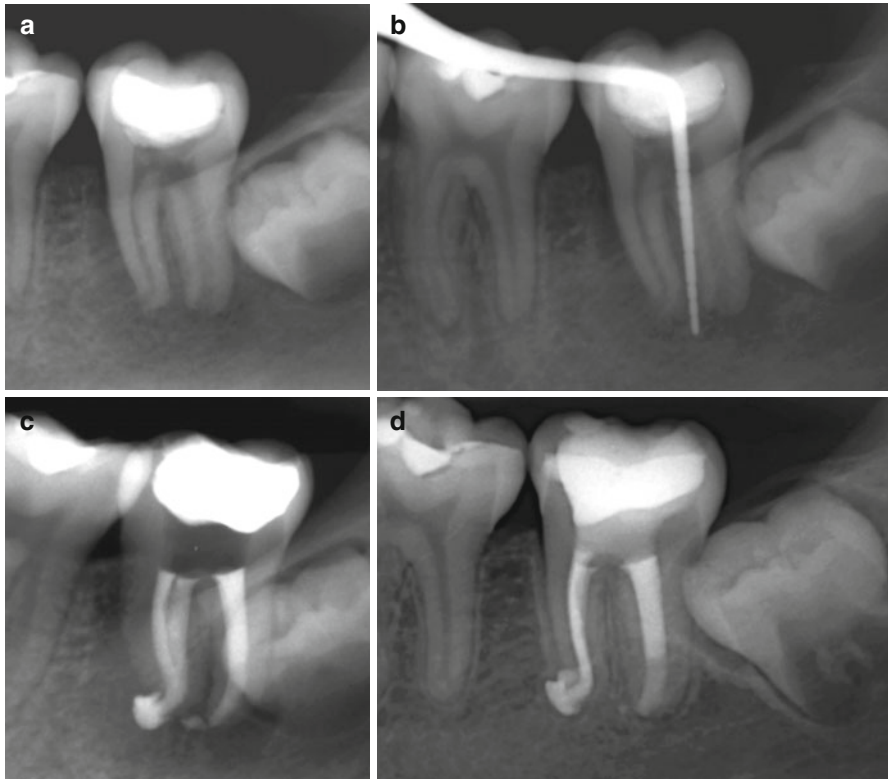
Clinical treatment of a mandibular second molar with pulp necrosis and a large apical canal size (a). The periodontal probe was placed in a deep periodontal pocket (b). The final radiograph (c) and a 2-year follow-up (d) show placement of a MTA barrier in the distal canal and evidence of osseous healing
